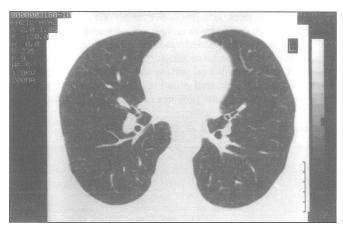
Control HRCT scan.
